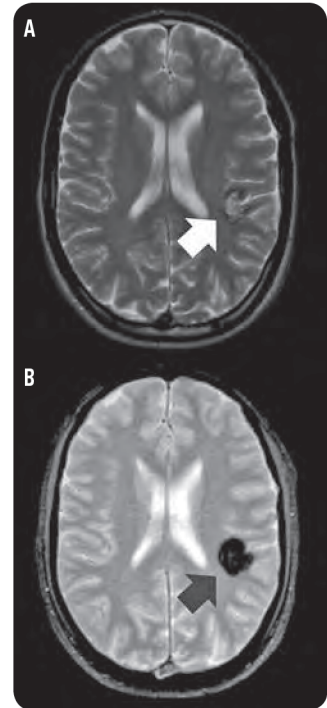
MRI of cavernous malformation
